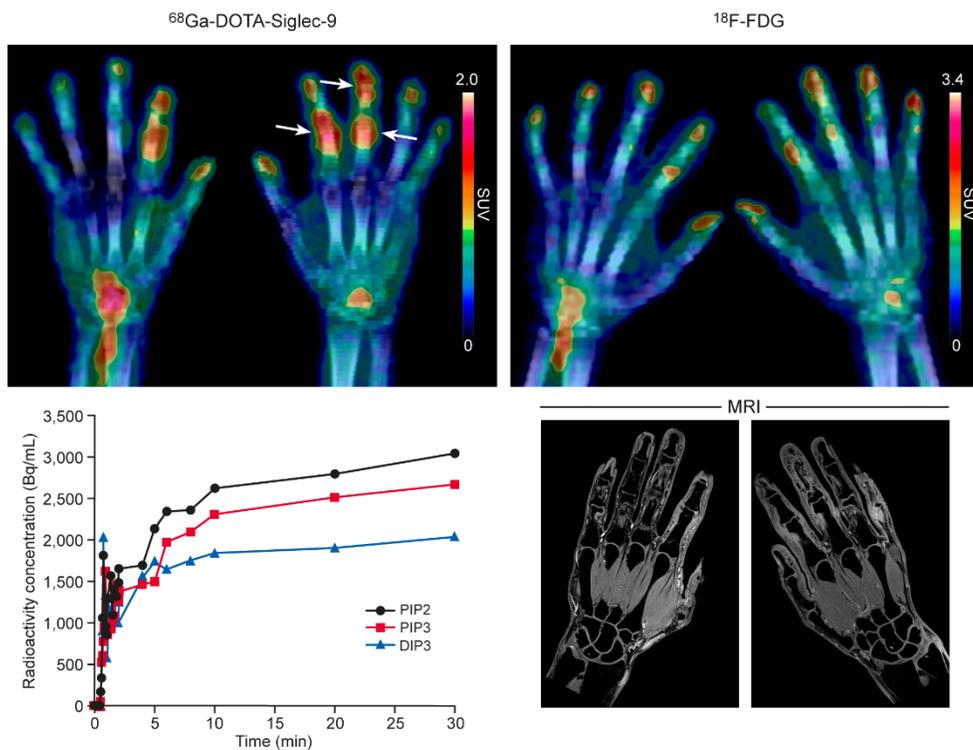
^{68}Ga -DOTA-Siglec-9 and ^{18}F -FDG PET/CT and MR images of the hands of a 49-year-old patient with early RA. White arrows denote proximal interphalangeal joints PIP2, PIP3 and distal interphalangeal joint DIP3 whose time-activity curves are in the lower left panel. Corresponding SUVs were 1.05, 0.92 and 0.70 with ^{68}Ga -DOTA-Siglec-9 and 1.46, 1.22 and 1.08 with ^{18}F -FDG, respectively.
